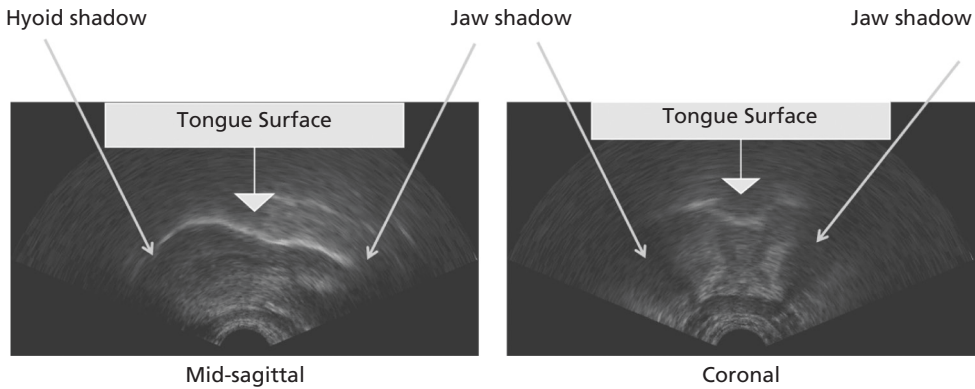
Midsagittal and coronal view of /s/ with ultrasound imaging.
